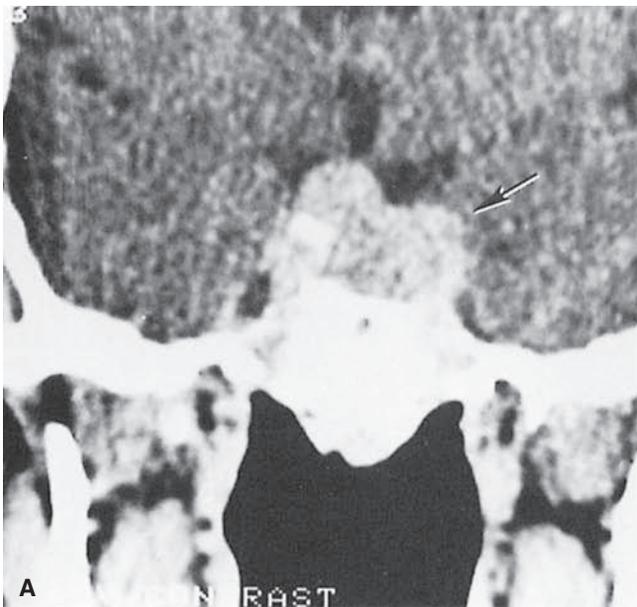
▲ A: Computed tomography scan showing a suprasellar pituitary tumor (*arrow*) in a thyroid-toxic patient with a thyroid-stimulating hormone (TSH)-secreting pituitary tumor. B: T1-weighted magnetic resonance image in the same patient showing a 2- x 2-cm pituitary tumor (*arrow*). T1-weighted images are favorable for demonstrating anatomical detail. (Adapted from Smallridge RC: Thyrotropin-secreting pituitary tumors. *Endocrinol Metab Clin North Am* 16:3, 1987.)
